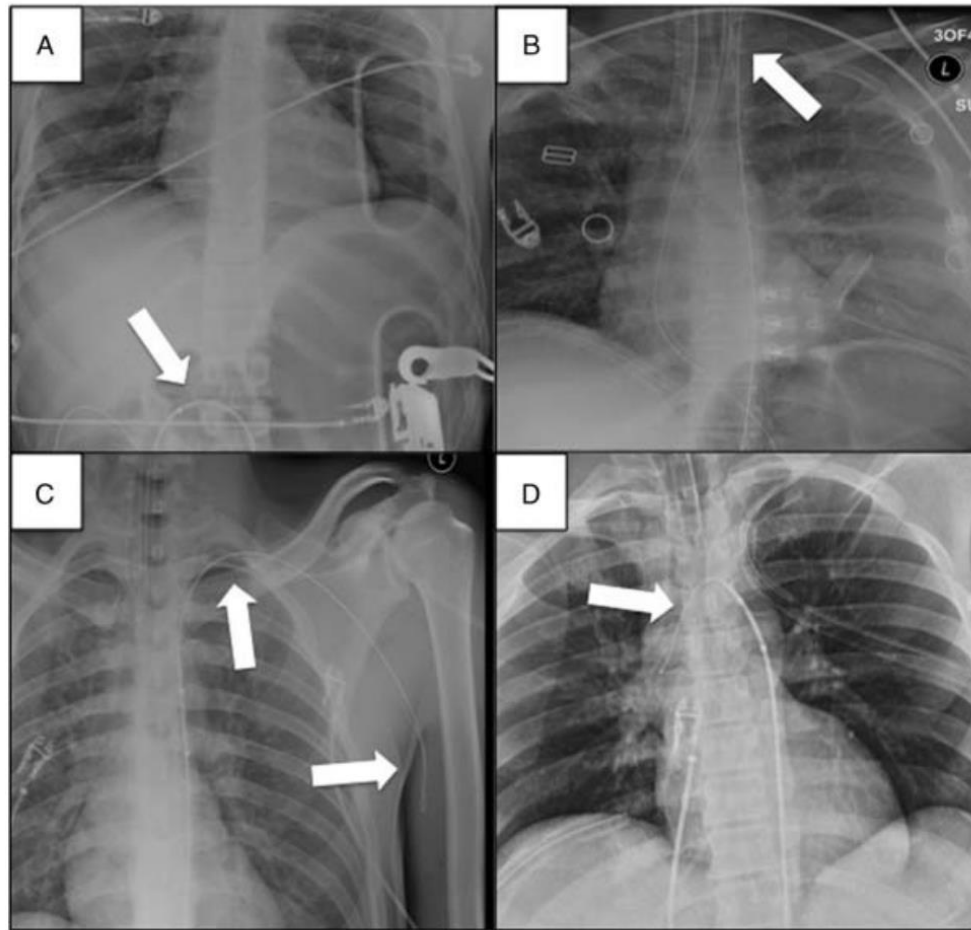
X-ray depictions of wire malposition. (A) Exit of the wire through an injury in the aorta. (B) Inadvertent advancement of the wire into the left carotid artery. (C) Inadvertent advancement of the wire into the left subclavian, axillary, and brachial artery. (D) Inadvertent advancement of the wire into the aortic arch. White arrows denote wire.
